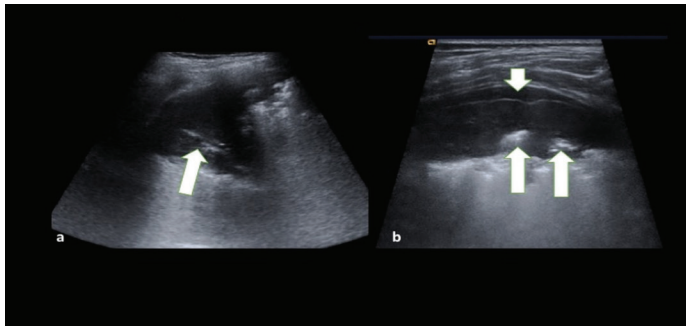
(a, b). 7-year-old girl; Ultrasound of the right middle zone through intercostal region shows the hypoechoic consolidation area with echogenic air bronchograms (arrows) by convex probe (a). The pleural effusion, echogenic irregular pleural line (short arrow) and hypoechoic consolidation area with air bronchograms (arrows) are demonstrated by linear probe (b).
